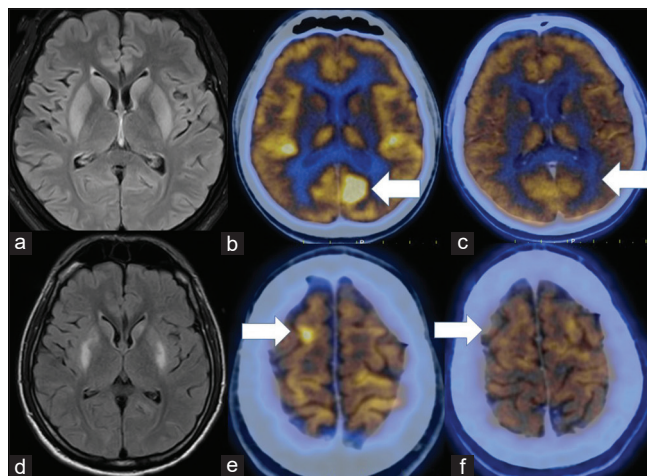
Top panel- Panel a: Initial FLAIR MRI; Symmetrical hyperintensities involving the bilateral putamina and caudate nuclei. PET CT images b: hypermetabolic area in occipital cortex (cuneus). Panel c: hypermetabolic area in the right frontal cortex. Bottom panel- FLAIR MRI (d) on day 20; mild interval reduction in the hyperintensities involving the bilateral putamina and caudate nuclei. PET CT images, at day 40-. e: Metabolic resolution of the hypermetabolic area in the cuneus, f: Metabolic resolution of the hypermetabolic area in the right frontal cortex
